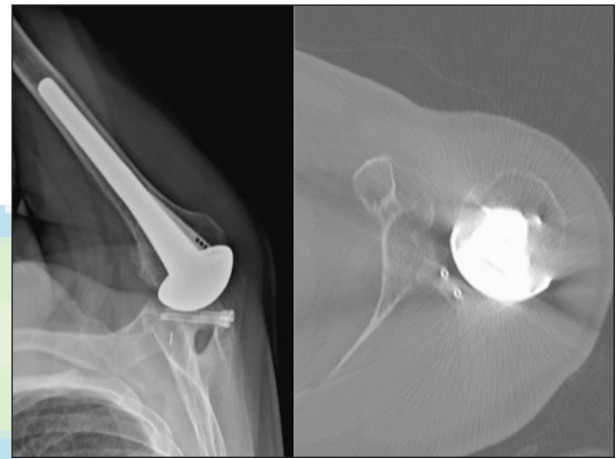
Postoperative X-ray and computed tomography scan demonstrating osseous integration and intact central peg
